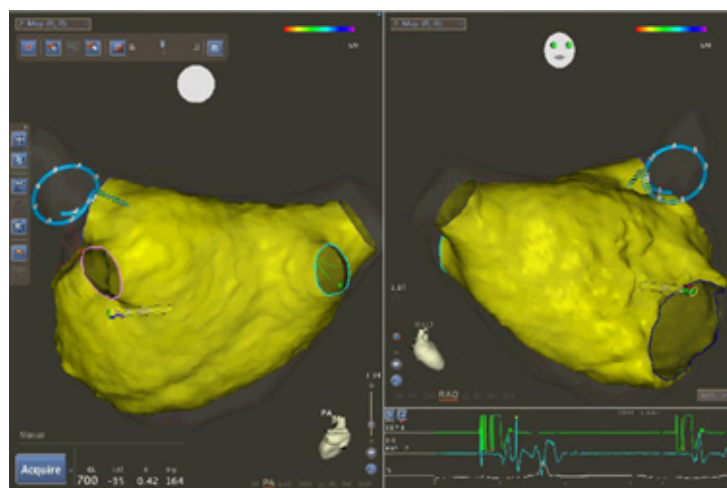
The Carto3 electroanatomic reconstruction obtained with the mapping catheters and the MRI are merged (postero-anterior and right anterior oblique views respectively); the system allows a reliable visualization of all the catheters inside the heart chamber. Yellow catheter, ablation catheter inside the left atrium; blue catheter, circular mapping catheter inside the left superior pulmonary vein
